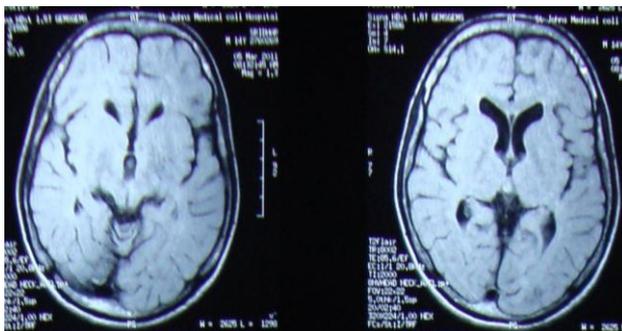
MRI images of brain showing mild cerebrum and cerebellum atrophy
